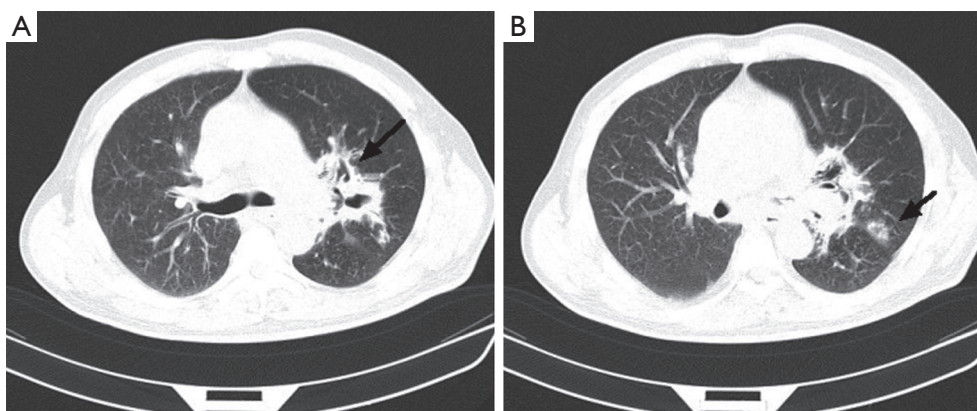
CT scan of the chest. (A) High-density shadow around the hilum of left lung (black arrow); (B) It appears that there is a hollow sign (black arrow) in the peripheral pulmonary. CT, computed tomography.
